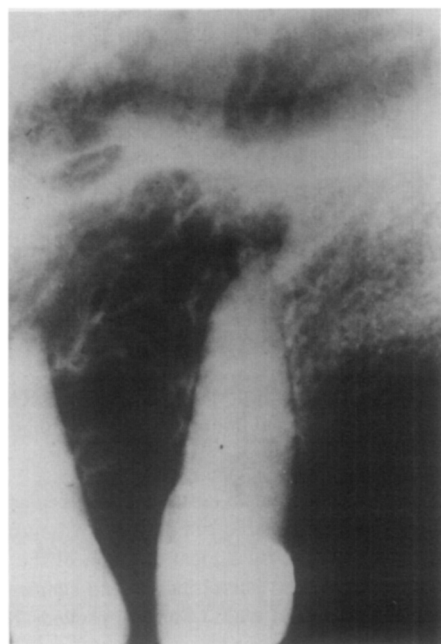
Radiograph shows multilocular radiolucency in left maxillary alveolar process.
